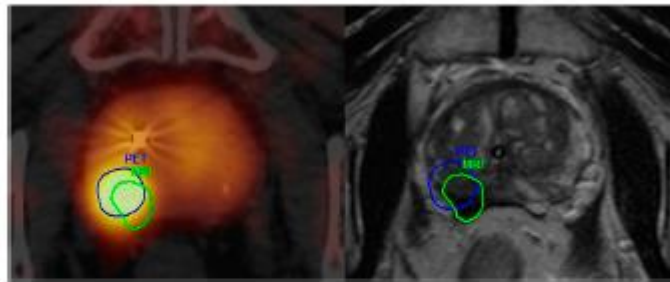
A patient who had positron emission tomography (PET)/CT before androgen deprivation therapy. The dominant intraprostatic lesion identified visually on PET overlaps the corresponding lesion identified on MRI.
